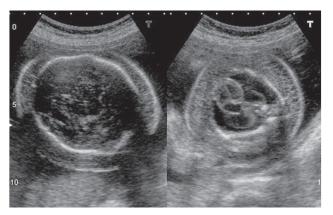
(b): Transverse ultrasonographic sections of the head (left) and chest (right) of the foetus with hydrops foetalis. Note the halo around the head due to oedema. The chest shows gross skin oedema and a large, bilateral pleural effusion.
